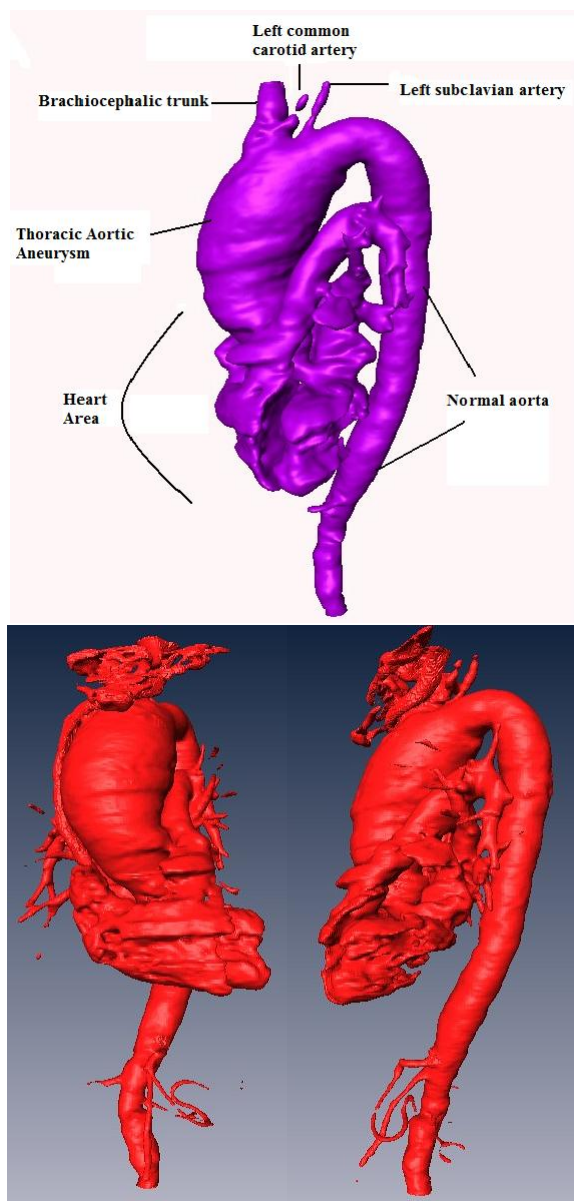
Aortic aneurysm, obtained after segmenting CT scans in AMIRA
